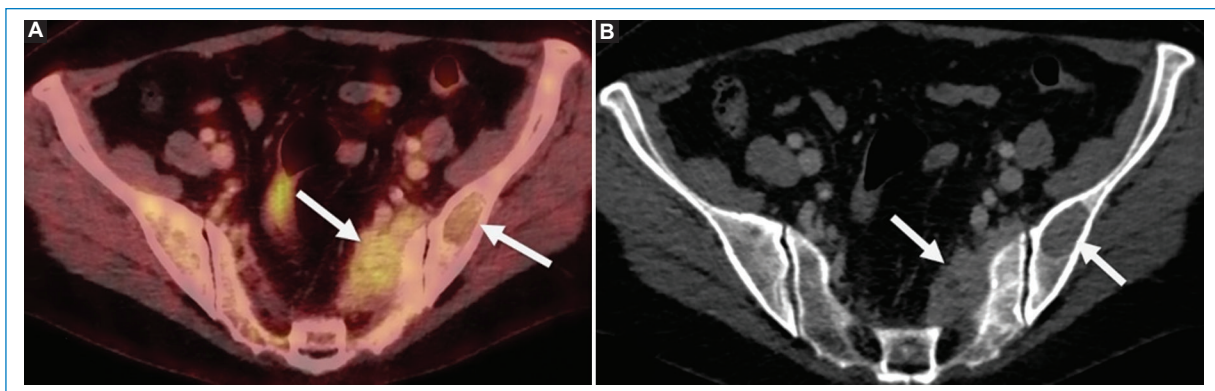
FDG PET/CT fusion and axial CT of the pelvis showing a left iliac osteolytic lesion and a left presacral soft tissue lesion with poor tracer uptake (arrows in A and B).
